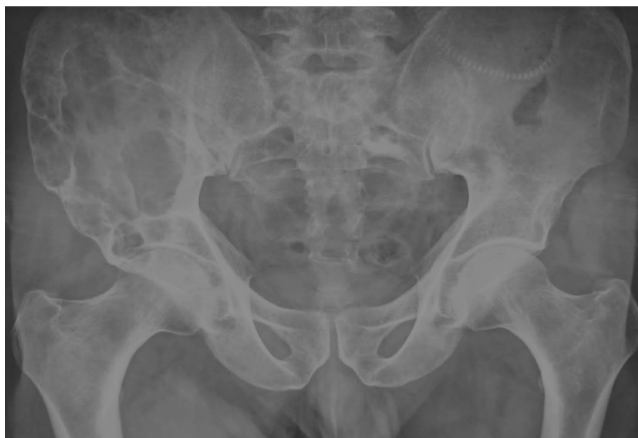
Standard X-ray of the pelvis in frontal view, showing poorly defined areolar lytic images, achieving the classic "honeycomb" appearance. There is no periosteal reaction or regional calcifications.
